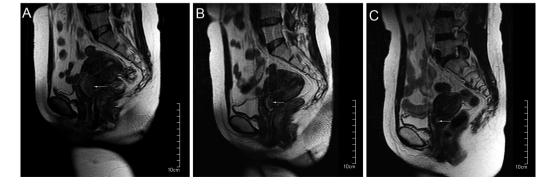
Sagittal magnetic resonance imaging of pelvis before (A, Jun 6th, 2014), during (B, July 25^{th} , 2014) and after (C, January 26^{th} , 2015) radiation therapy.
